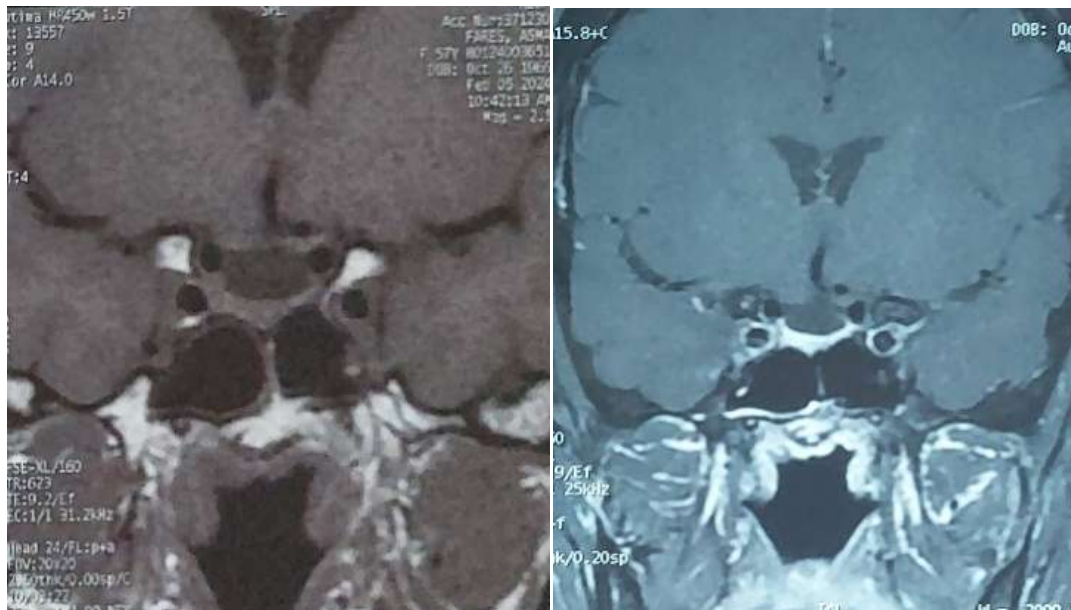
T1-weighted coronal section before and after injection of Gadolinium.
